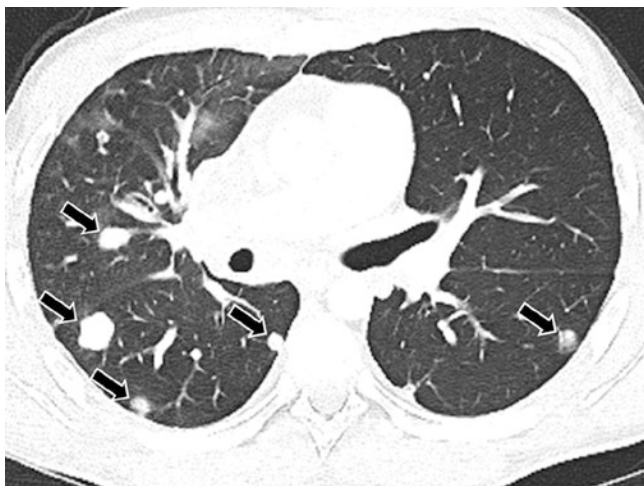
A 13-year-old boy with right femoral osteosarcoma. Axial lung window CT image shows multiple pulmonary nodules (arrows) consistent with metastatic disease
